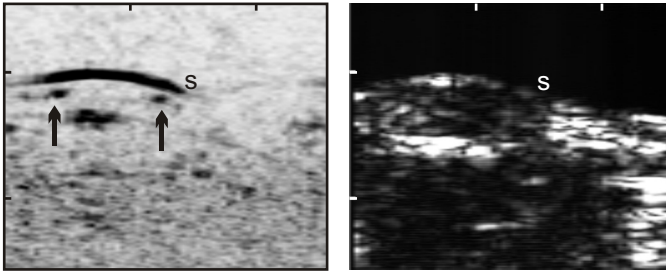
In-vivo* optoacoustic image (left) and ultrasound image (right) of a human index finger (palm towards transducer). The images cover a 2.6×2.0 cm area. On the optoacoustic image (left) the skin is visible as an arc shaped black line (s). 1 mm below the skin the Vv. digitales palmares are visible as two black dots on either side of the finger (arrows). They are accompanied by the corresponding Aa. digitales palmares propriae, which appear much fainter (tiny dots besides veins) because of the reduced absorption of oxyhemoglobin at 760 nm wavelength. 3 mm below the skin, a blood perfused region possibly the periosteum is visible. The four vessels and the periosteum are hard to see on the corresponding ultrasound image (right). The ultrasound image is predominated by the echo signal from the skin (s) and the large echo signal from the bone 5 mm below it. The skin surface position matches well on both images, it is however obvious that the two methods extract complementary information. In the lower part of the optoacoustic image the noise floor becomes visible because of the applied depth gain correction. The skin and blood vessels appear possibly enlarged by saturation effects of strong optoacoustic signals. The contrast of the ultrasound images was increased by gamma adjustment. This was not necessary for the optoacoustic images. The complete optoacoustic image was acquired in real-time with three 15 mJ laser pulses (3x continuous averaging).
